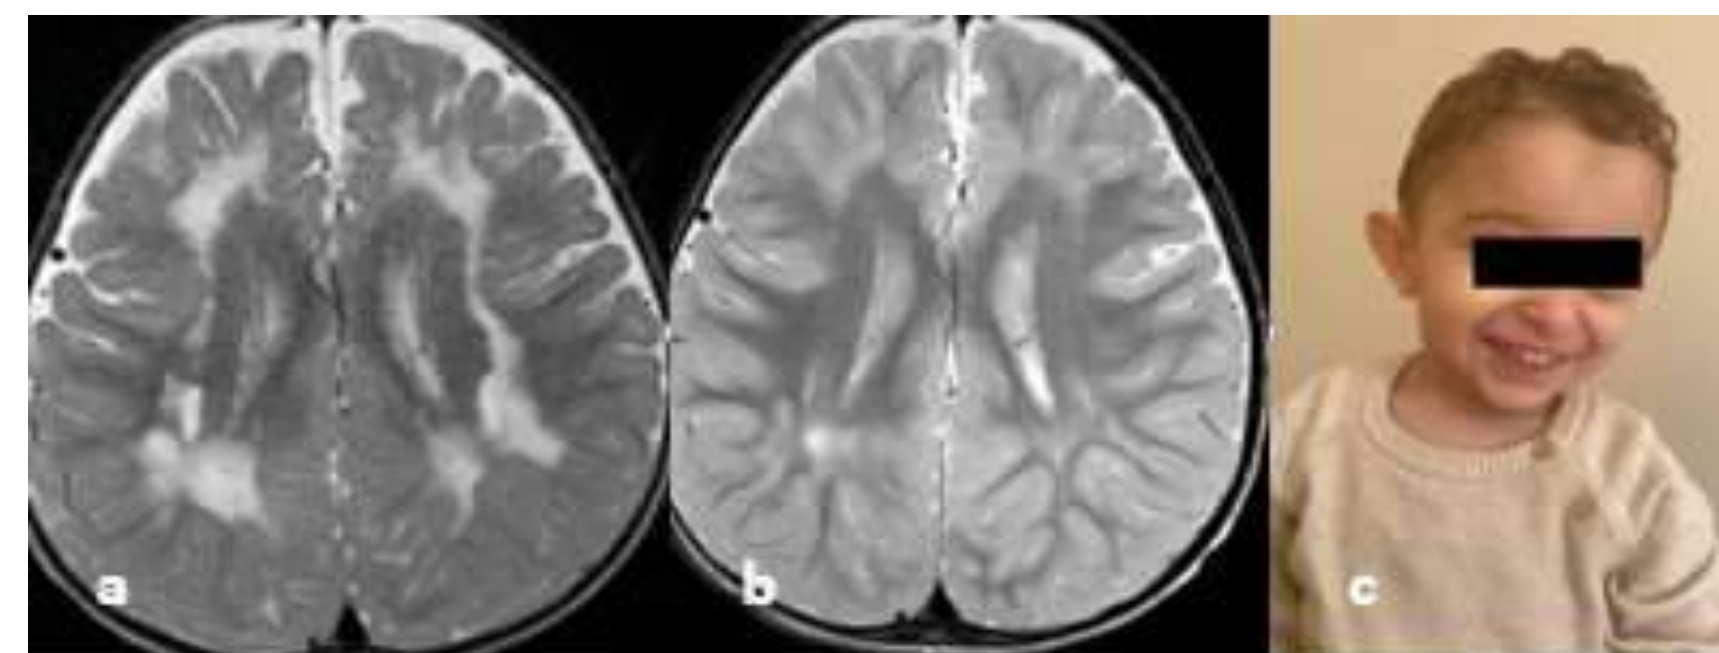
a-Cranial Magnetic Resonance Imaging (MRI) at 14 months (Axial T2), b-cranial MRI at 26 months (Axial T2), MRI lesions had regressed over time, c-Patient's photograph.
